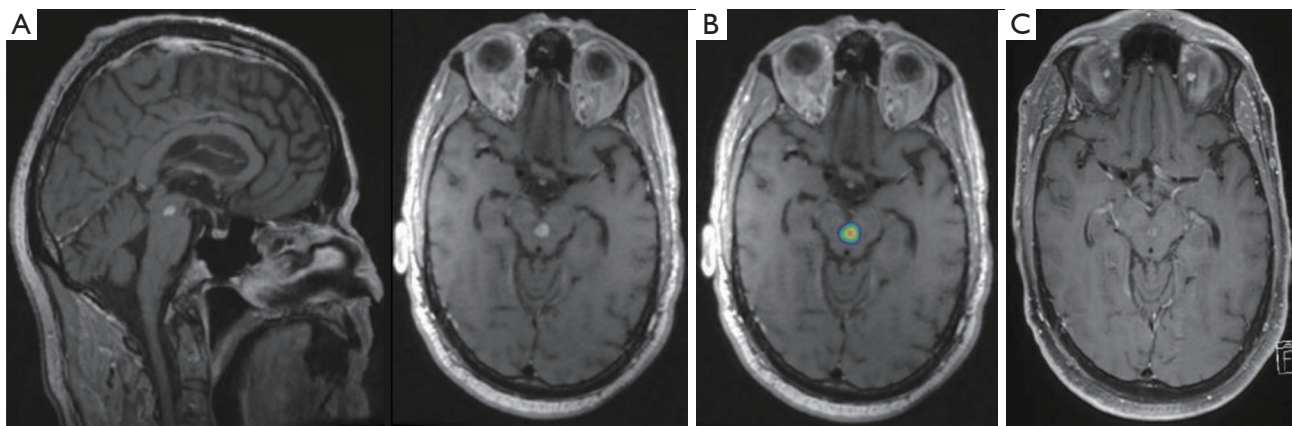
T1-weighted MRI images of patient with a metastatic lesion in midbrain, before and after radiosurgery. (A) Sagittal and axial images of patient with lung adenocarcinoma metastatic to the central midbrain, (B) treated with 27 Gy in 3 fractions of linear accelerator-based radiosurgery. (C) Significant decrease in size and gadolinium enhancement was noted 6 months following radiosurgery. MRI, magnetic resonance imaging.
